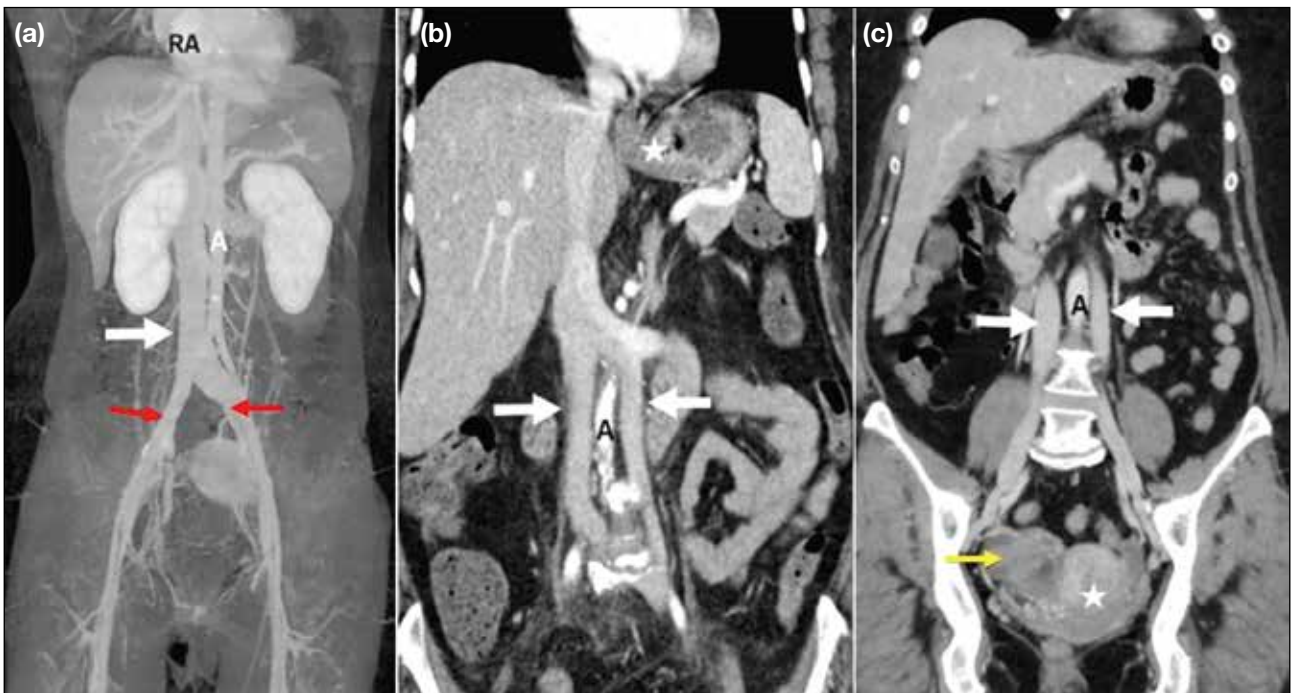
Coronal maximum intensity projection contrast-enhanced computed tomography images of the abdomen. (a) Normal inferior vena cava (IVC) [white arrow] to the right of the aorta (A), formed by the confluence of the bilateral common iliac veins (red arrows), draining into the right atrium (RA). (b) Duplication of the IVC (white arrows) in a patient with gastric malignancy (star). The left infrarenal IVC crosses the midline anterior to the aorta (A) and joins the right IVC. (c) Duplication of the IVC (white arrows) on both sides of the aorta (A) in a patient with endometrial malignancy (star) and a complex right ovarian cyst (yellow arrow).
